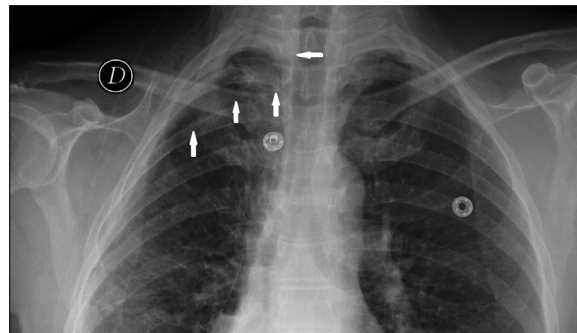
Chest radiography showing the position of the paravertebral catheter (arrows) before attempting its removal.
